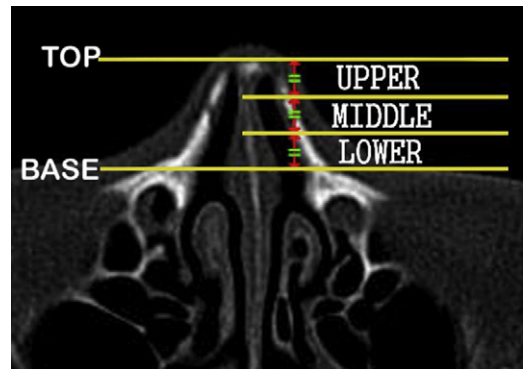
Division of the nose for radiographic classification of nasal fractures and clinical application via axial CT. (From Han DS, Han YS, Park JH. A new approach to the treatment of nasal bone fracture: radiologic classification of nasal bone fractures and its clinical application. *J Oral Maxillo Surg* 2011;69(11):2841–47; with permission.)
